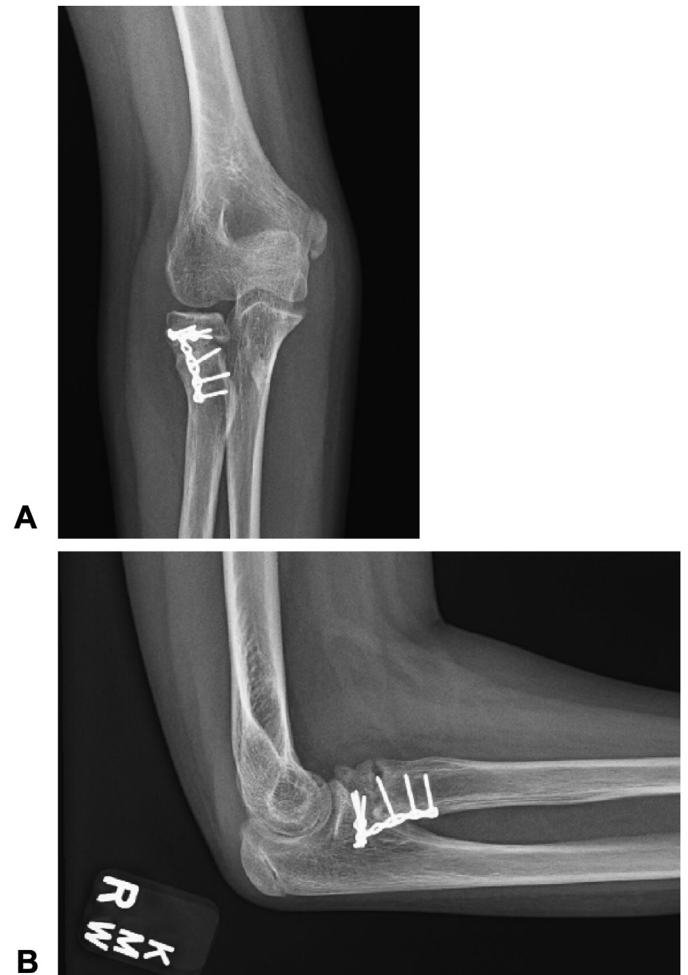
Postoperative PA (A) and lateral (B) radiographs demonstrating radiocapitellar dislocation.
